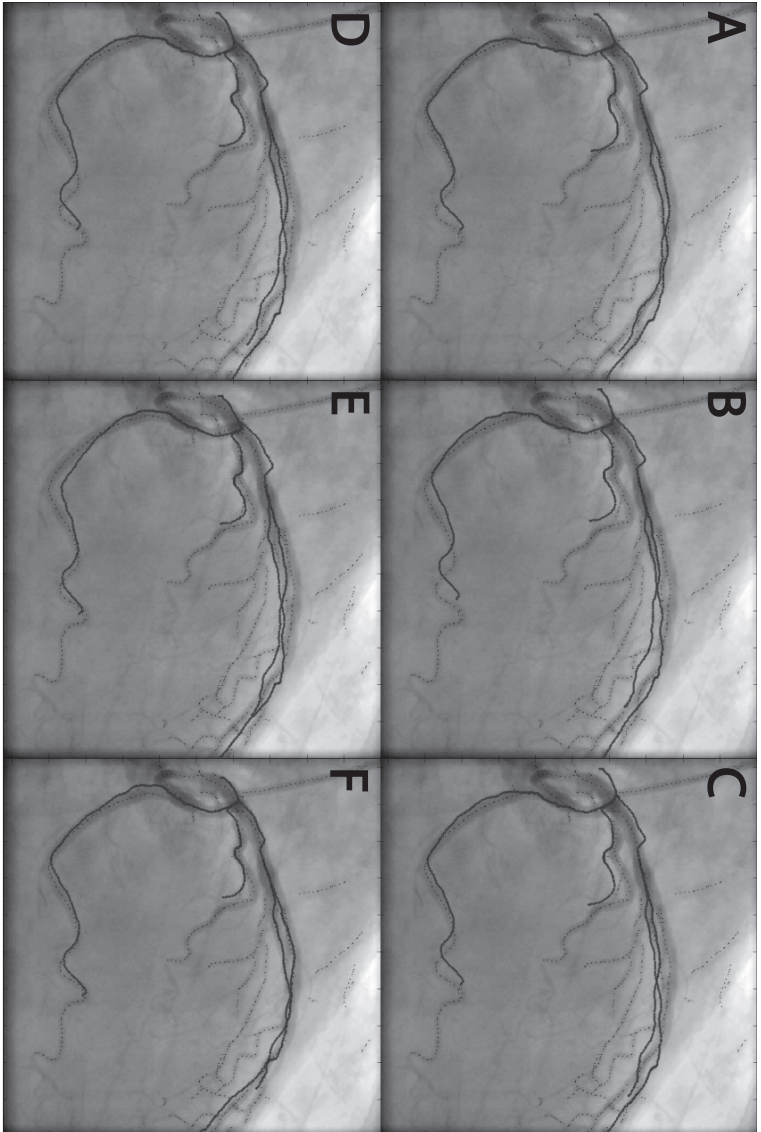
(color version on page 159): Example alignments with all coronary motion models and the quadratic respiratory model. The blue lines are the fitted coronary arteries overlaid on the corresponding systolic X-ray frame. Black dots show the subsampled centerlines used for fitting. A) 4D CTA motion, B) mean motion, C) predicted motion, D) static end-diastolic estimate, E) statistical motion model, F) conditional motion model.
